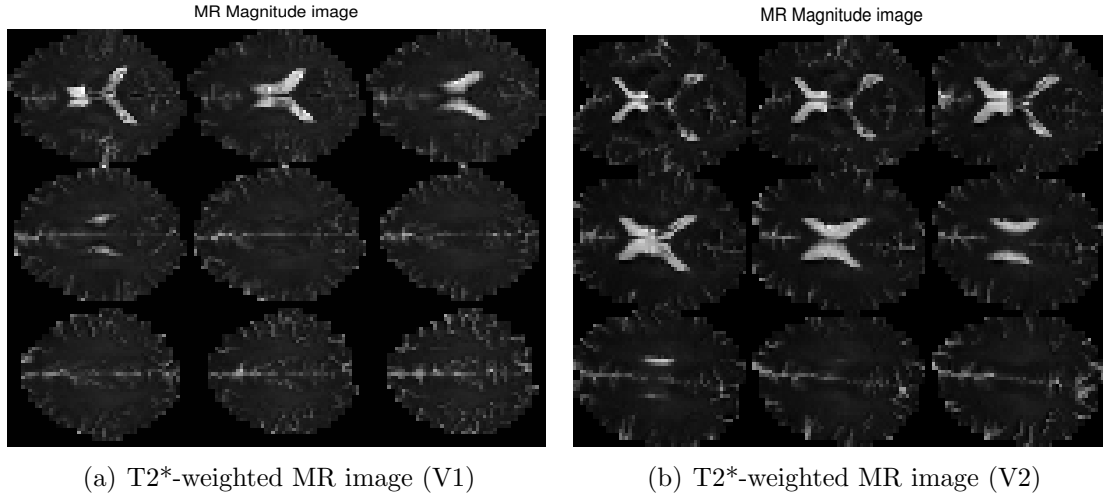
T2*-weighted MR images of the *in-vivo* healthy brains: (a) first volunteer (b) second volunteer
